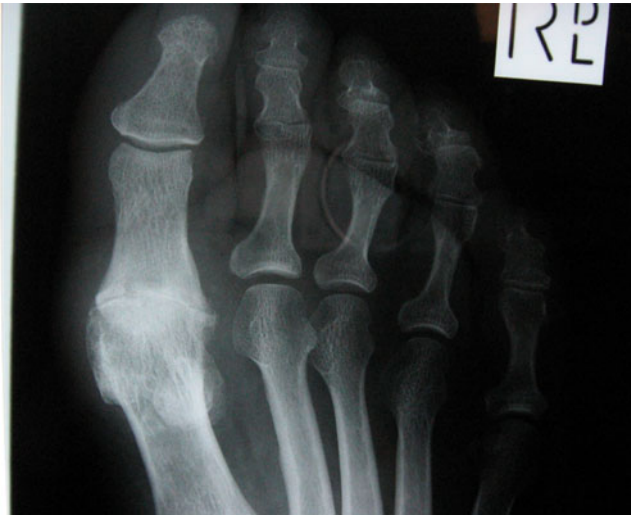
Preoperative anteroposterior (AP) radiograph of patient with grade IV arthritis of the first metatarsophalangeal joint
